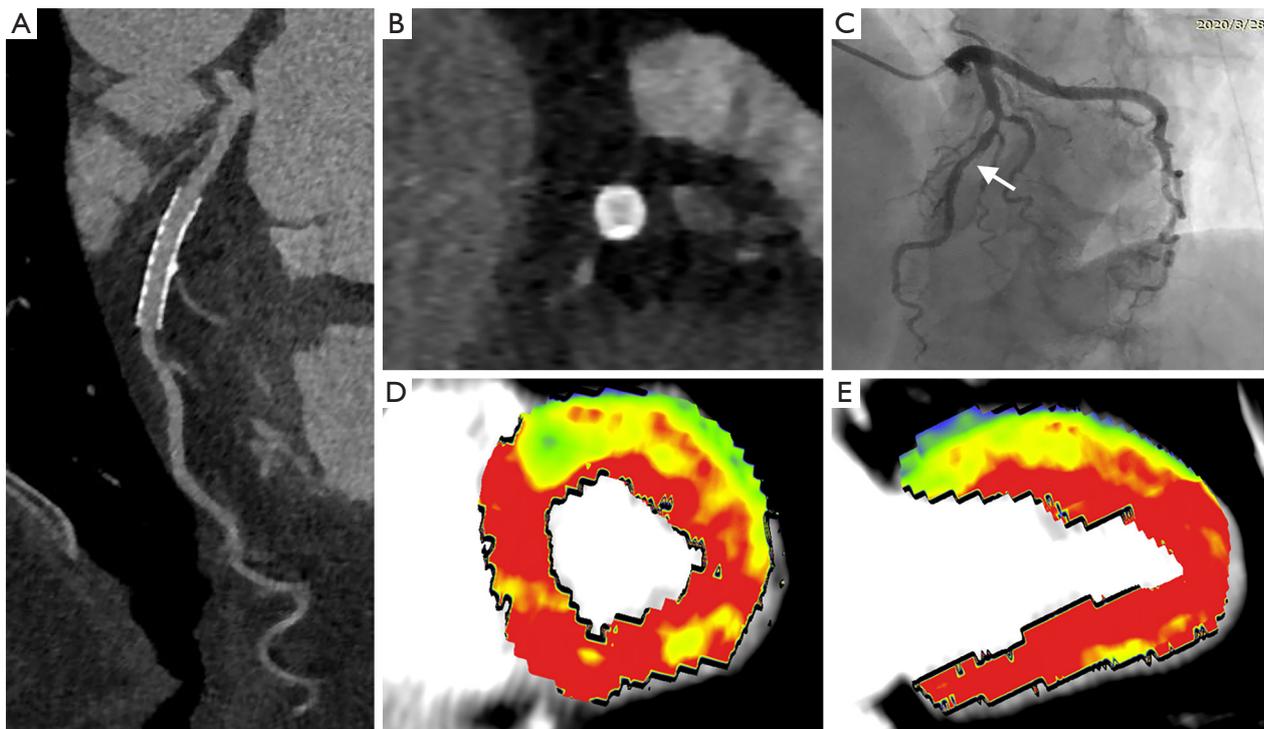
A 44-year-old male with normal myocardial perfusion 13 months after PCI. (A,B) CPR and cross-sectional images of follow-up CCTA revealed patent stent at the middle LAD. (C) The baseline ICA showed focal severe stenosis at the middle LAD (white arrow). The baseline peak hs-cTnI level was 0.04 ng/L. (D,E) Follow-up dynamic CT-MPI revealed normal myocardial perfusion of the anterior wall (MBF: mL/100 mL/min). PCI, percutaneous coronary intervention; CPR, curved planar reformation; CCTA, coronary computed tomography angiography; LAD, left anterior descending; ICA, invasive coronary angiography; hs-cTnI, high-sensitivity cardiac troponin I; ISR, in-stent restenosis; CT, computed tomography; MPI, myocardial perfusion imaging; MBF, myocardial blood flow.
